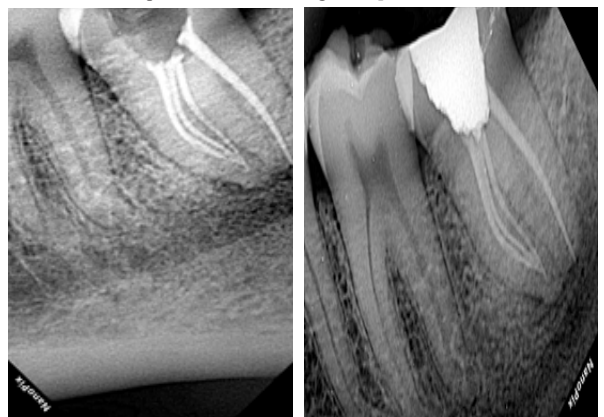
Obturation Radiograph
